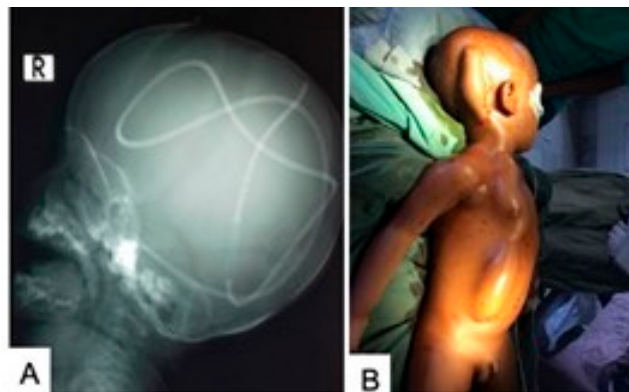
(A) X-Ray shows total migration of shunt tube within the brain. (B) Picture shows accommodation of CSF within the subcutaneous tunnel because of lower end block. Source: Figure by authors.
